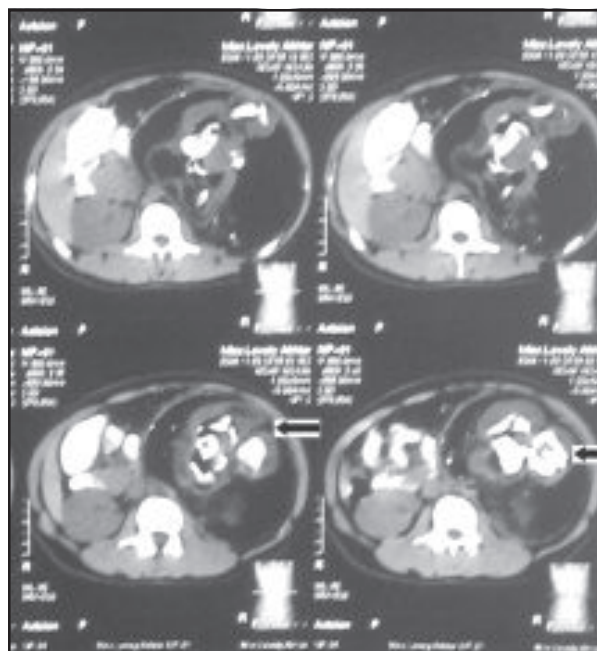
Abdominal CT. Left sided abdominal mass-mature cystic dermoid (arrow) showing (?) spine, long bones and base of the skull.
